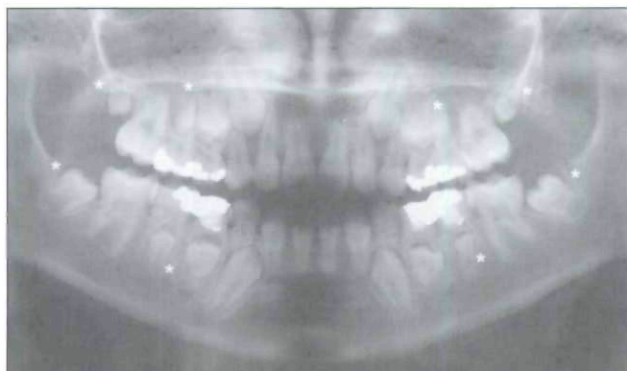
Representative panoramic radiograph of a 2-year-old patient at diagnosis who received chemotherapy and 1,800 cGy. Notice microdontia of maxillary and mandibular second premolars and second molars (asterisks).
